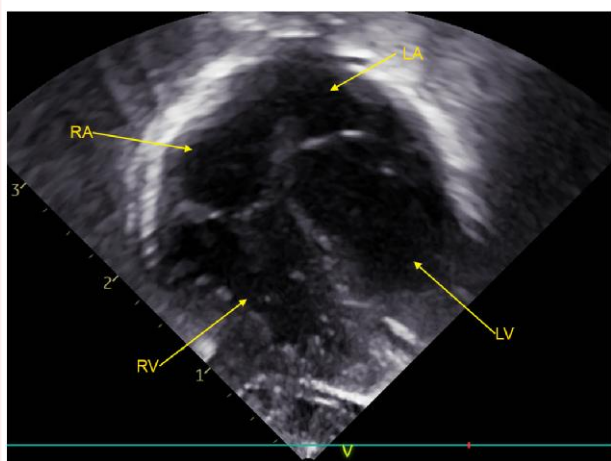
Apical four-chamber view (AV valves closed) showing no mass in the right atrium at 5.7 days' age. RA, right atrium; RV, right ventricle; LA, left atrium; and LV, left ventricle.
